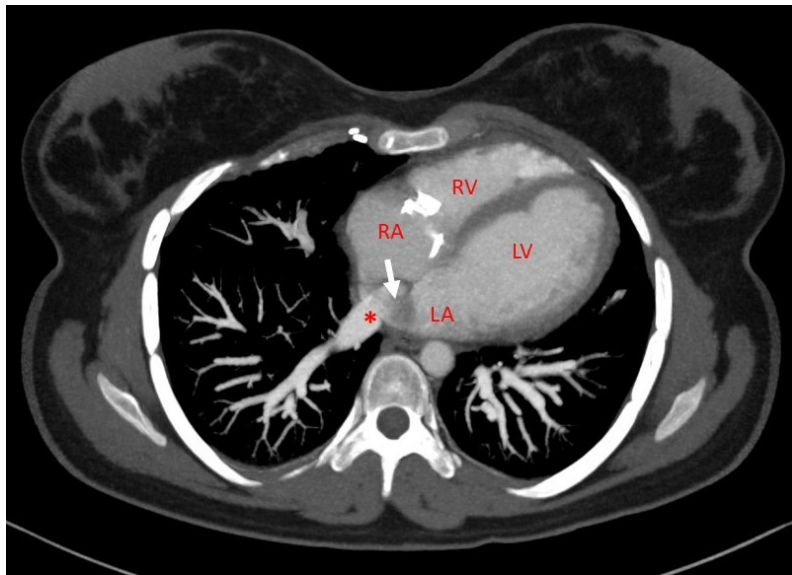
CT Angiography Axial MPR (Multiplanar Reformation) image- IVC (white arrow) seen opening into left atrium close to opening of right inferior pulmonary vein (red star). (abbreviation: RA- right atrium, LA- left atrium, RV- right ventricle, LV- left ventricle).
